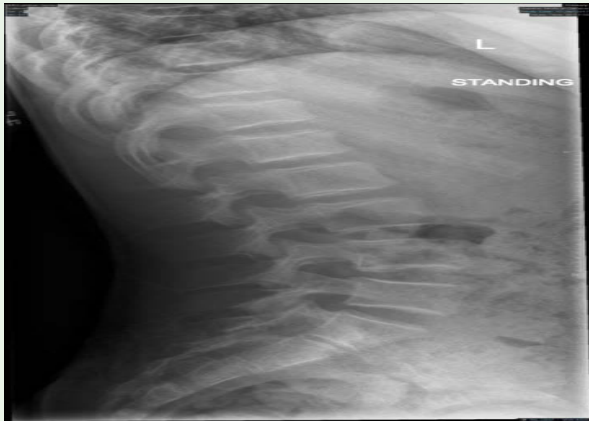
Lateral radiograph of the thoraco-lumbar spine shows the effects of bone softening and resultant compression of vertebrae by adjacent intervertebral disks (arrows).
